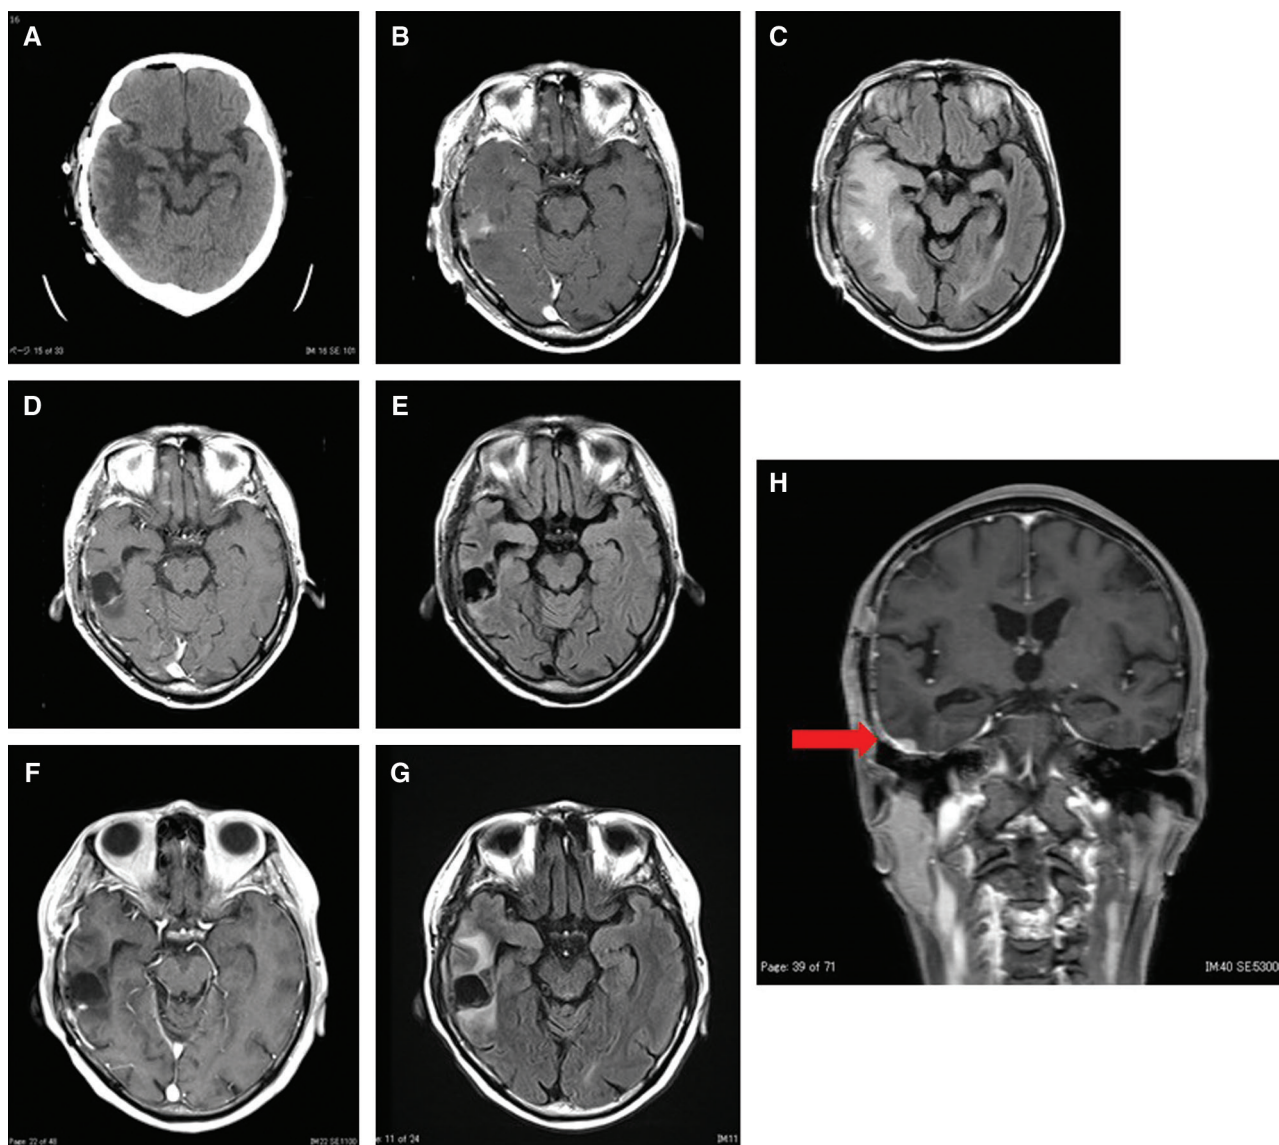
Postoperative images. (A–C) Postoperative MRI showing removal of the tumor. (D and E) MRI at 1 month after surgery showing no recurrence of the tumor. (F–H) MRI at 3 months after surgery showing recurrence of the tumor at the middle fossa base (arrow). MRI: magnetic resonance imaging.
